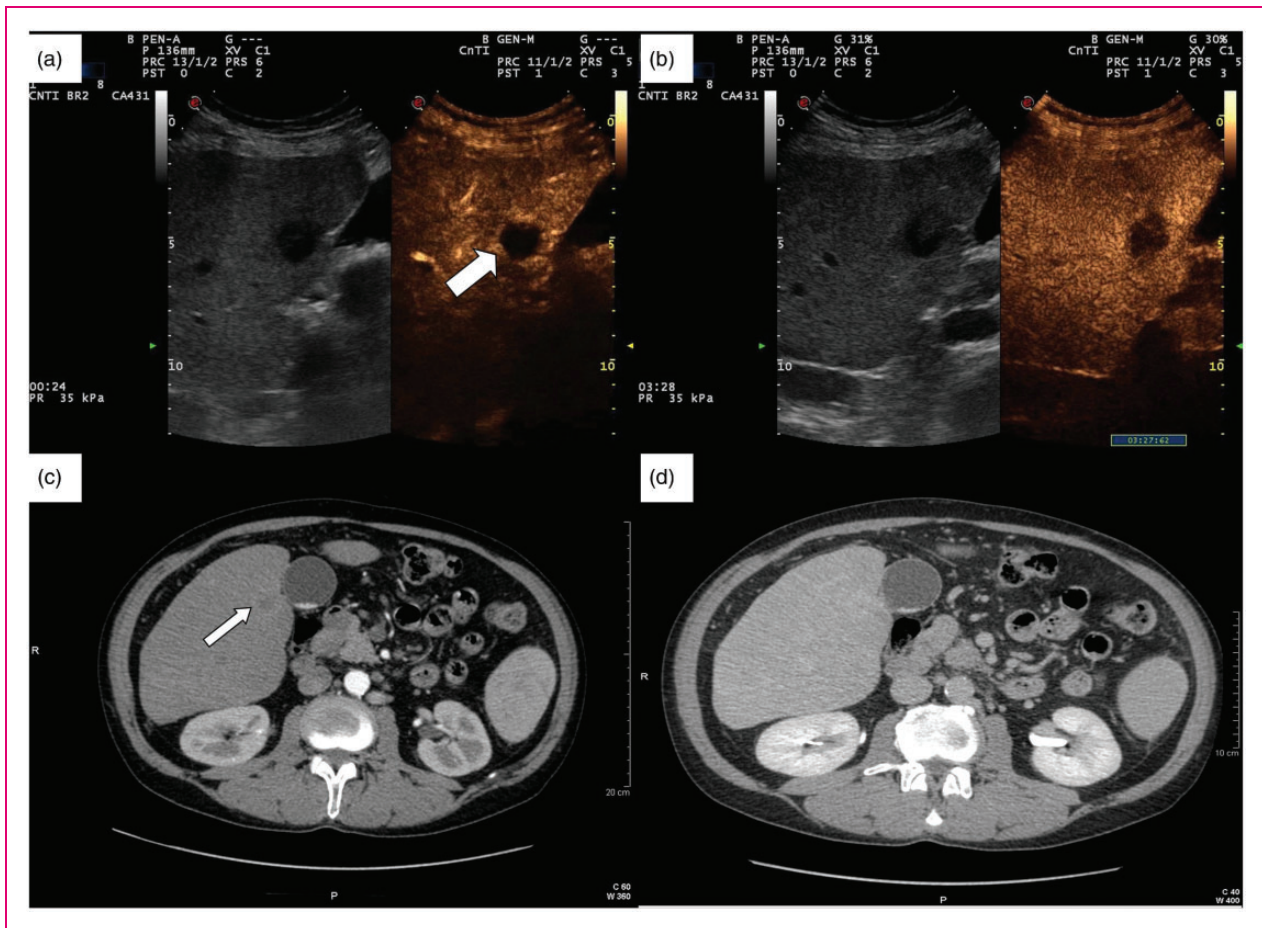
(a) Contrast-enhanced ultrasound (CEUS) rim-like appearance of a combined hepatocellular–cholangiocellular carcinoma (CHC) nodule during the arterial phase (white thick arrow). (b) The enhancement of the rim fades out in late phase (3 min 26 sec post-injection), with a persistently hypoechoic central area. (c) Contrast-enhanced computed tomography (CT) of the same CHC nodule shows a mild arterial rim-like enhancement (thin arrow). (d) The enhancement progresses towards being mild homogeneous centripetal during the portal-late phase.
